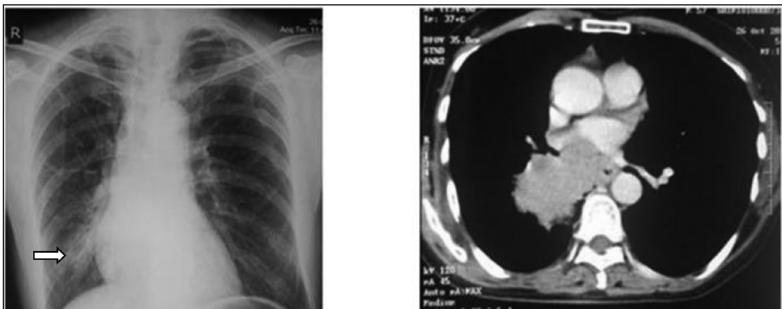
Chest X-ray – showing inhomogeneous ill-defined opacity right lower zone
